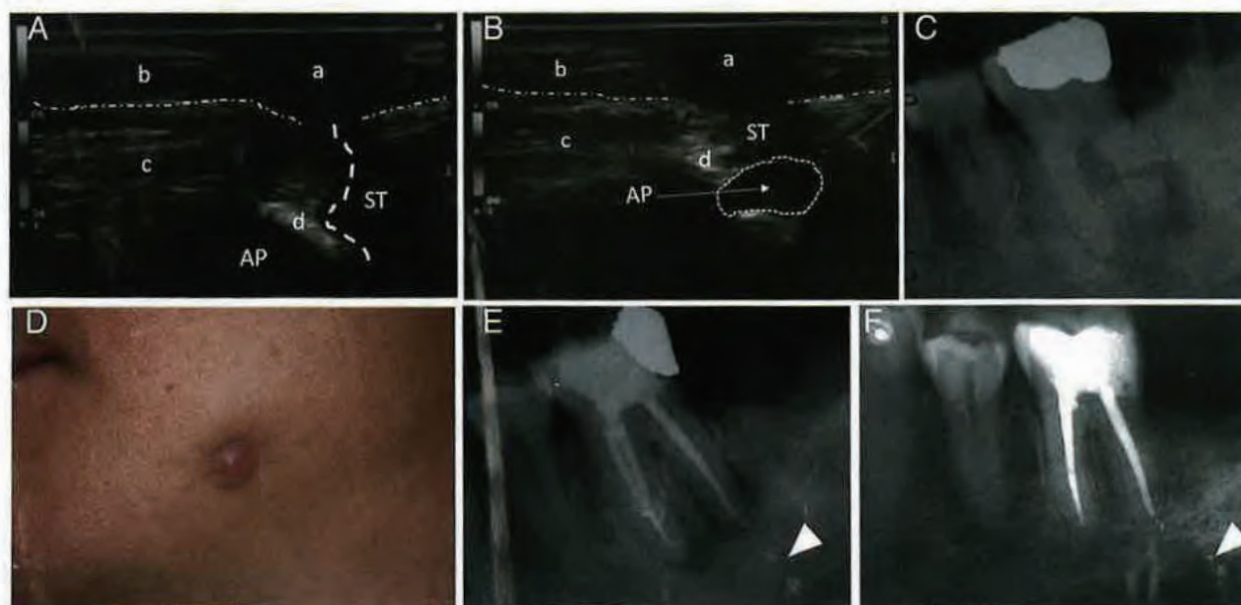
(A) An ecographic image of an extraoral ST (interrupted line) representing the (a) opening at the (b) skin surface (fragmented contour) in the (c) muscular layer and the (d) mandibular bone. (B) Another perspective of the same lesion showing the whole AP (interrupted contour). (C) A periapical radiograph of the same lesion on tooth #18. (D) Clinical image of the cutaneous stoma. (E) A postoperative ecographic image showing the extruded root canal sealer following the ST (arrowhead). (F) A 3-month postoperative radiograph showing the progressive movement of the sealer (arrowhead) and healing of the lesion.
